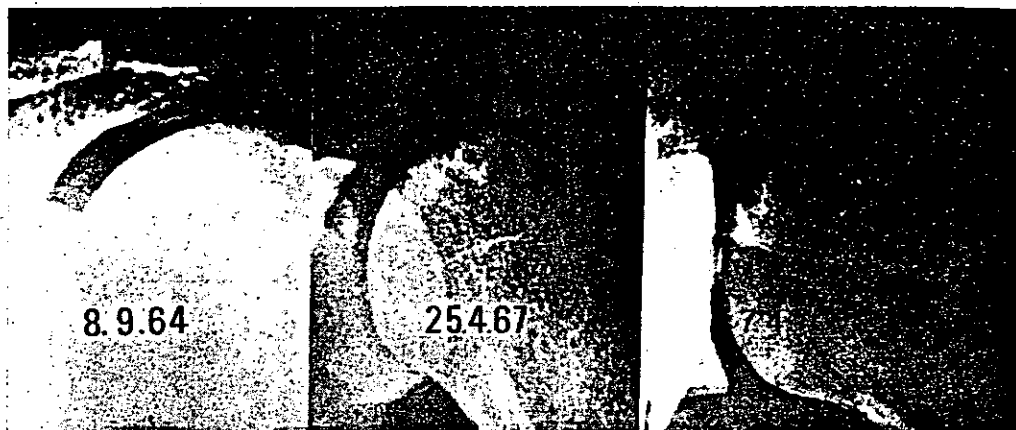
Serial radiographs. On the left the humeral head is underpenetrated, trabecular detail is not seen and it is impossible to identify possible osteonecrosis; in the centre a better quality radiograph has defined positive osteonecrosis with spherical segmental opacities adjacent to an intact articular cortex – positioning is unsatisfactory with overlying glenoid; on the right positioning is better but the radiograph is grossly overpenetrated and the lesion is not well defined.
